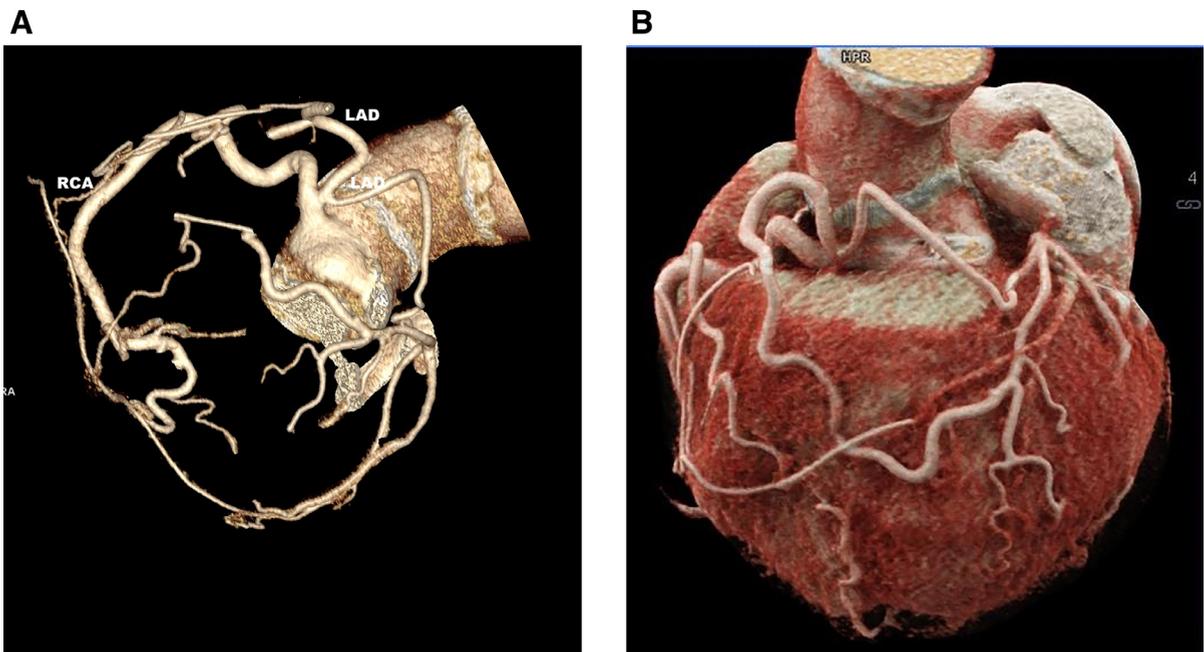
Single coronary artery type Lipton type R2-A. (A, B) Coronary computed tomography angiography, volume-rendered reconstructions show the left anterior descending artery taking-off from the right coronary artery. LAD = left anterior descending artery; LCx = left circumflex artery; RCA = right coronary artery.
